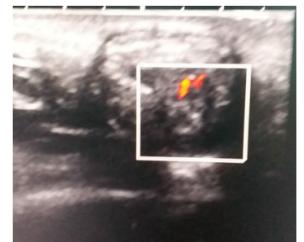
On colour doppler USG image mild internal vascularity seen in the centre of lesion
